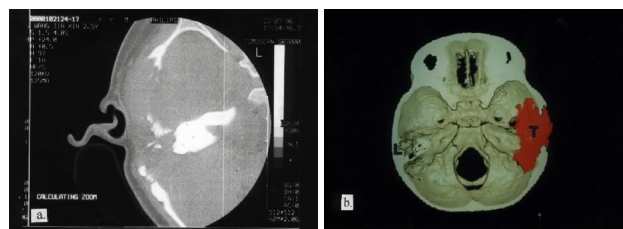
Right side eosinophilic granuloma. a) Regular CT image showing extensive erosion of bone. b) Three dimensional CT reconstructed image showing erosion of the tegmen tympani, squamous temporal bone and medial skull base lateral to the foramen lacerum.
